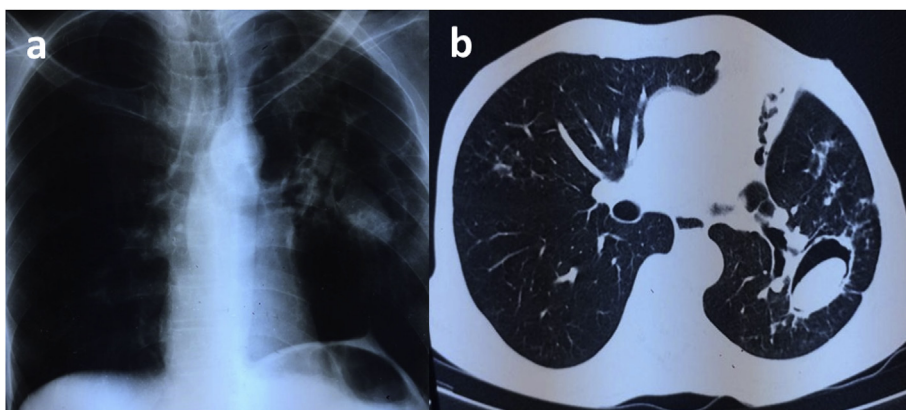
a) Chest xray showing left apical cavitation and features of pulmonary fibrosis. b) Chest CT scan showing a cavity on the left upper lobe containing an ovoid soft tissue density mass with a crescentic lucency superior to the mass. There appears to be a volume loss on the ipsilateral lung with a compensatory hyperinflation on the right seen crossing the midline anteriorly. The bronchial walls of the bronchi arising from the left hilum are dilated.
